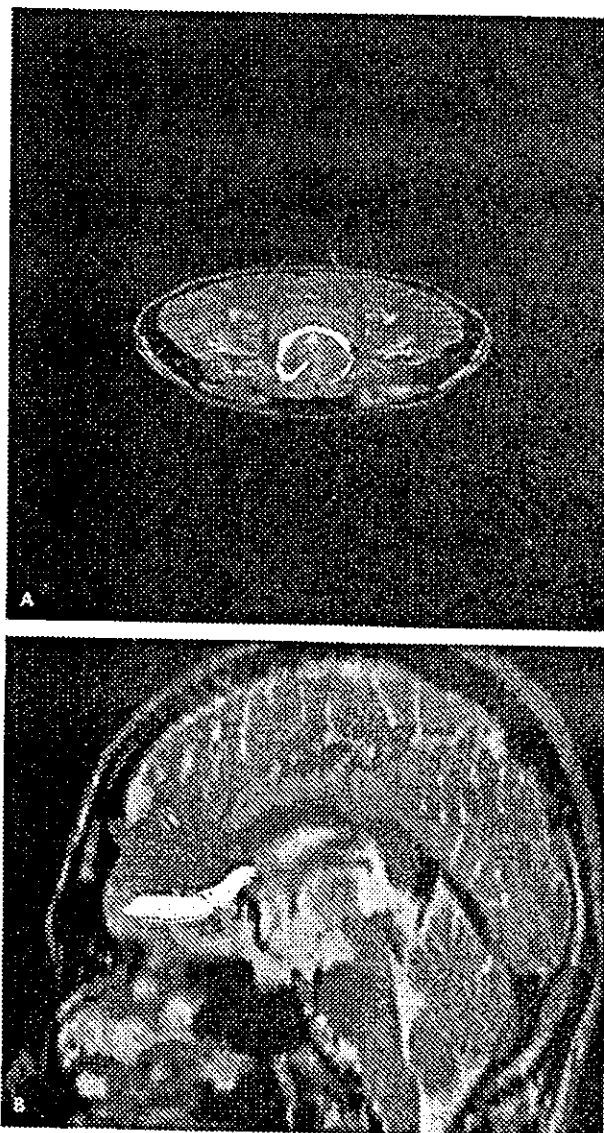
Diffusion tensor tractography through the genu and the rostrum of the corpus callosum. The frontal (A) and lateral (B) views are overlaid on axial and sagittal T2-weighted fast spin echo images, respectively. The tracking lines crossing through the ventral half of the genu (shown in red) commonly passed along the medial course to frontal lobe, and those through the dorsal half (shown in blue) passed along the lateral course. The lines crossing through the rostrum (shown in yellow) ran along the more inferior course compared with the forceps minor and seemed to go into the orbital surfaces of the frontal lobes.
